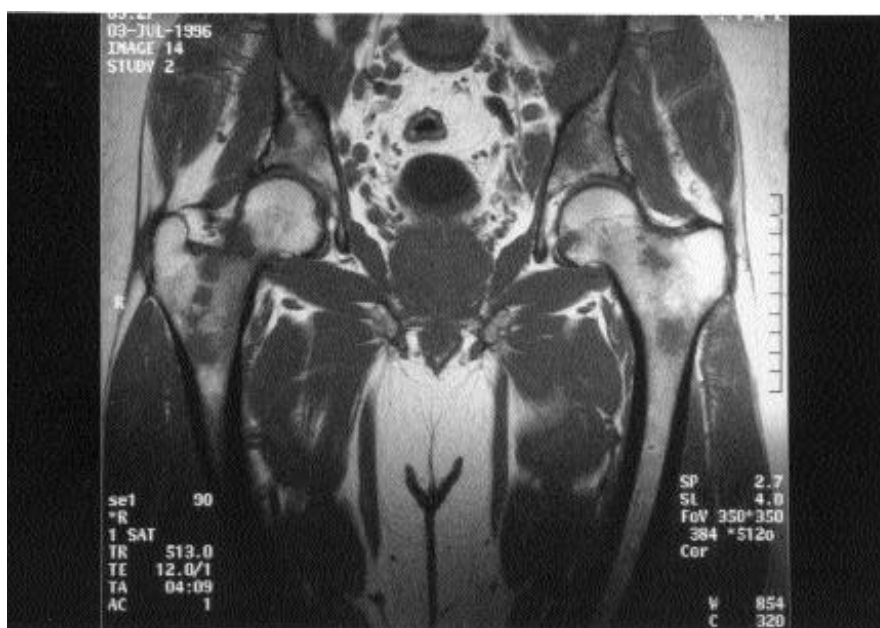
T1 weighted MRI of the pelvis.
